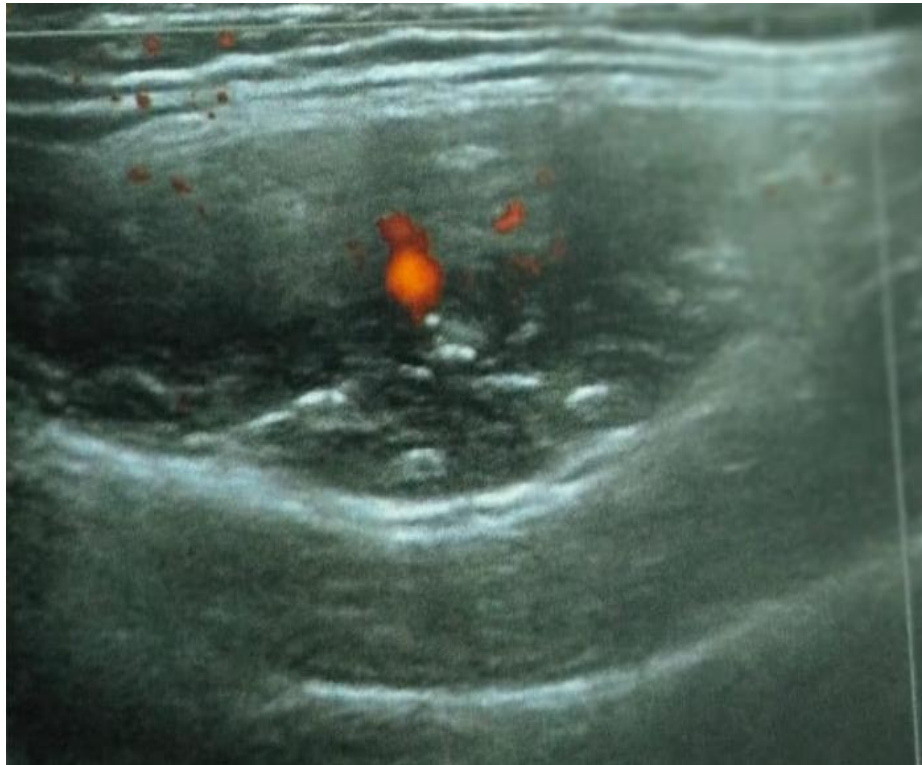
Ultrasound Appearance of the Mass
